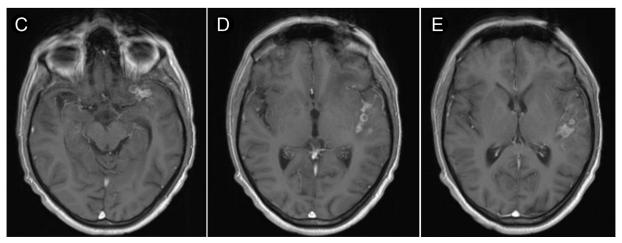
Follow-up MRI brain shows (A) T2 FLAIR images: Regression of left peri-insular temporal lobe edema and development of left frontal subcortical edema. (B) SWI: Persistent but less blood products. (C-E) Post Gad images: Nodular and cystic rim enhancing lesions in the left insular fissure and adjacent CSF spaces.
